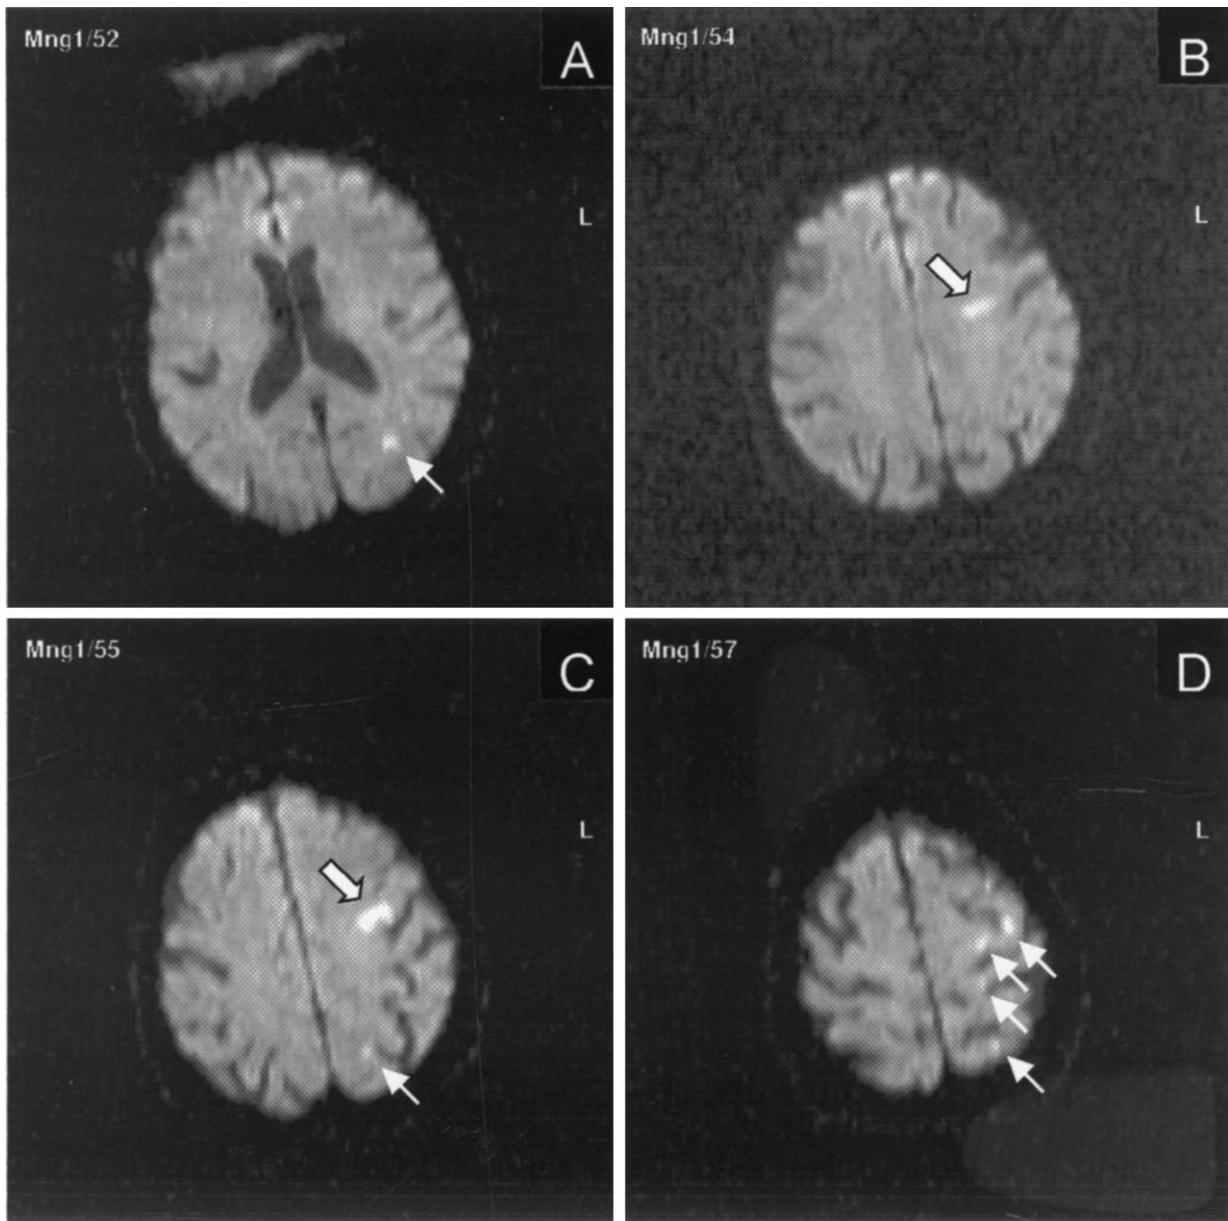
Postinterventional magnetic resonance imaging scans in Patient #6 (Table 2) showing ischemic lesions (arrows) in several tomographic layers. The open arrows in panels B and C both denote the largest lesion found in this patient, which extends over two adjacent layers, 5 mm apart.
